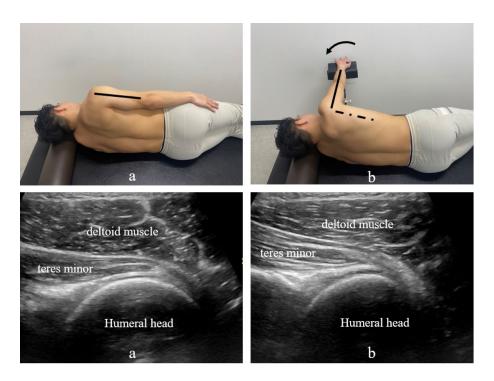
Limb position when delivering the radial pressure wave (RPW), and the ultrasound image of the area to be irradiated RPW for each limb position.
